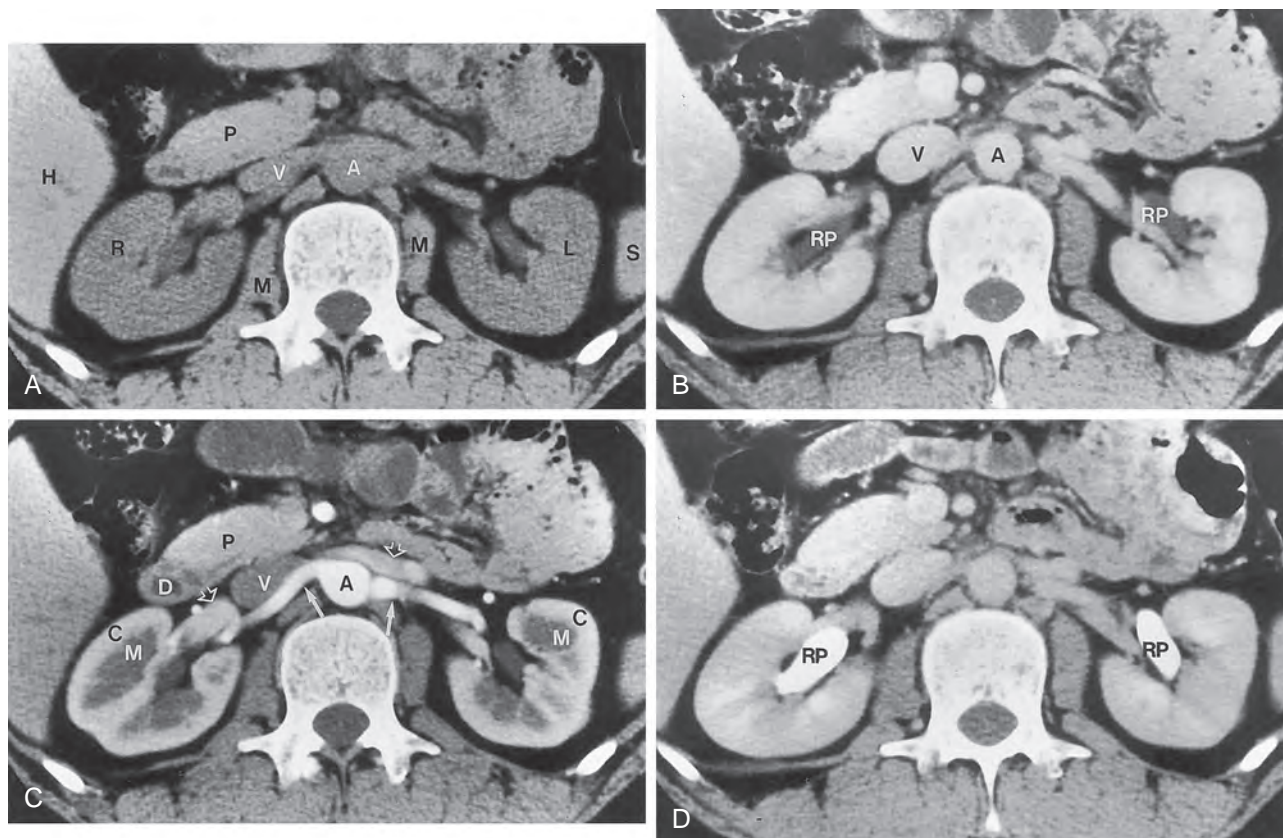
Renal computed tomography (CT) demonstrating normal nephrogenic progression. A, Unenhanced CT scan obtained at the level of the renal hilum shows right (R) and left (L) kidneys of CT attenuation values slightly less than those of the liver (H) and pancreas (P). A, abdominal aorta; M, psoas muscle; S, spleen; V, inferior vena cava. B, Enhanced CT scan obtained during a cortical nephrographic phase, generally 25 to 80 seconds after contrast medium injection, reveals increased enhancement of the renal cortex (C) relative to the medulla (M). The main renal artery is indicated with *solid arrows* bilaterally. Main renal veins (*open arrows*) are less opacified with respect to the aorta (A) and arteries. D, duodenum; P, pancreas; V, inferior vena cava. C, CT scan obtained during the homogeneous nephrographic phase, generally between 85 and 120 seconds after contrast medium administration, reveals a homogeneous, uniform, increased attenuation of the renal parenchyma. The wall of the normal renal pelvis (RP) is paper thin or not visible on the CT scan. A, abdominal aorta; V, inferior vena cava. D, CT scan obtained during the excretory phase shows contrast medium in the renal pelvis (RP) bilaterally; this starts to appear approximately 3 minutes after contrast medium administration.
